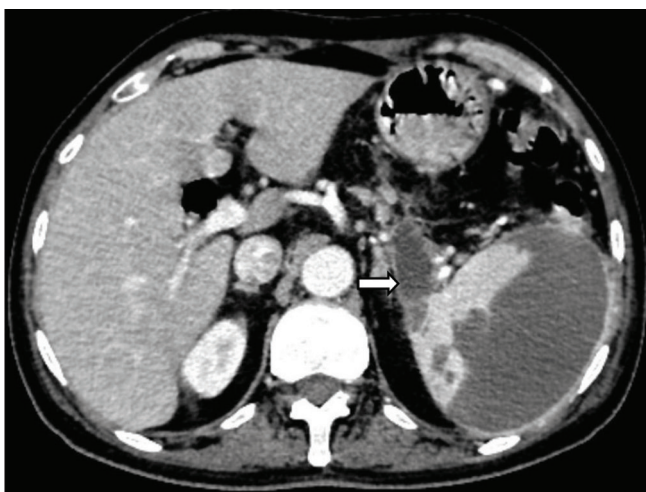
Contrast Axial CT section shows pseudocyst (Arrow) in tail of pancreas in close proximity to hilum of spleen and subcapsular splenic collection.
